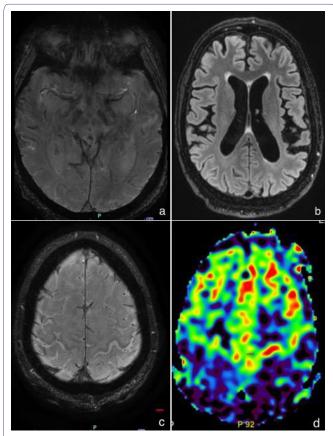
Follow up 3-Tesla brain MRI. a) Axial SWAN sequence showing the absence of the physiological hyperintensity in the intermediate portion of the left substantia nigra, indicating signs of degeneration in the nigrostriatal system at that level, while it remains recognizable on the right side. b) Axial FLAIR sequence highlighting bilateral frontoparietal atrophy, with greater severity on the left side. c) Axial SWAN sequence showing subtle cortical hypointensity in the bilateral primary motor cortex, the anterior post central gyri, and the posterior middle frontal gyri. d) Axial CBF image revealing hypoperfusion in the parietal lobes, notably on the left side.
